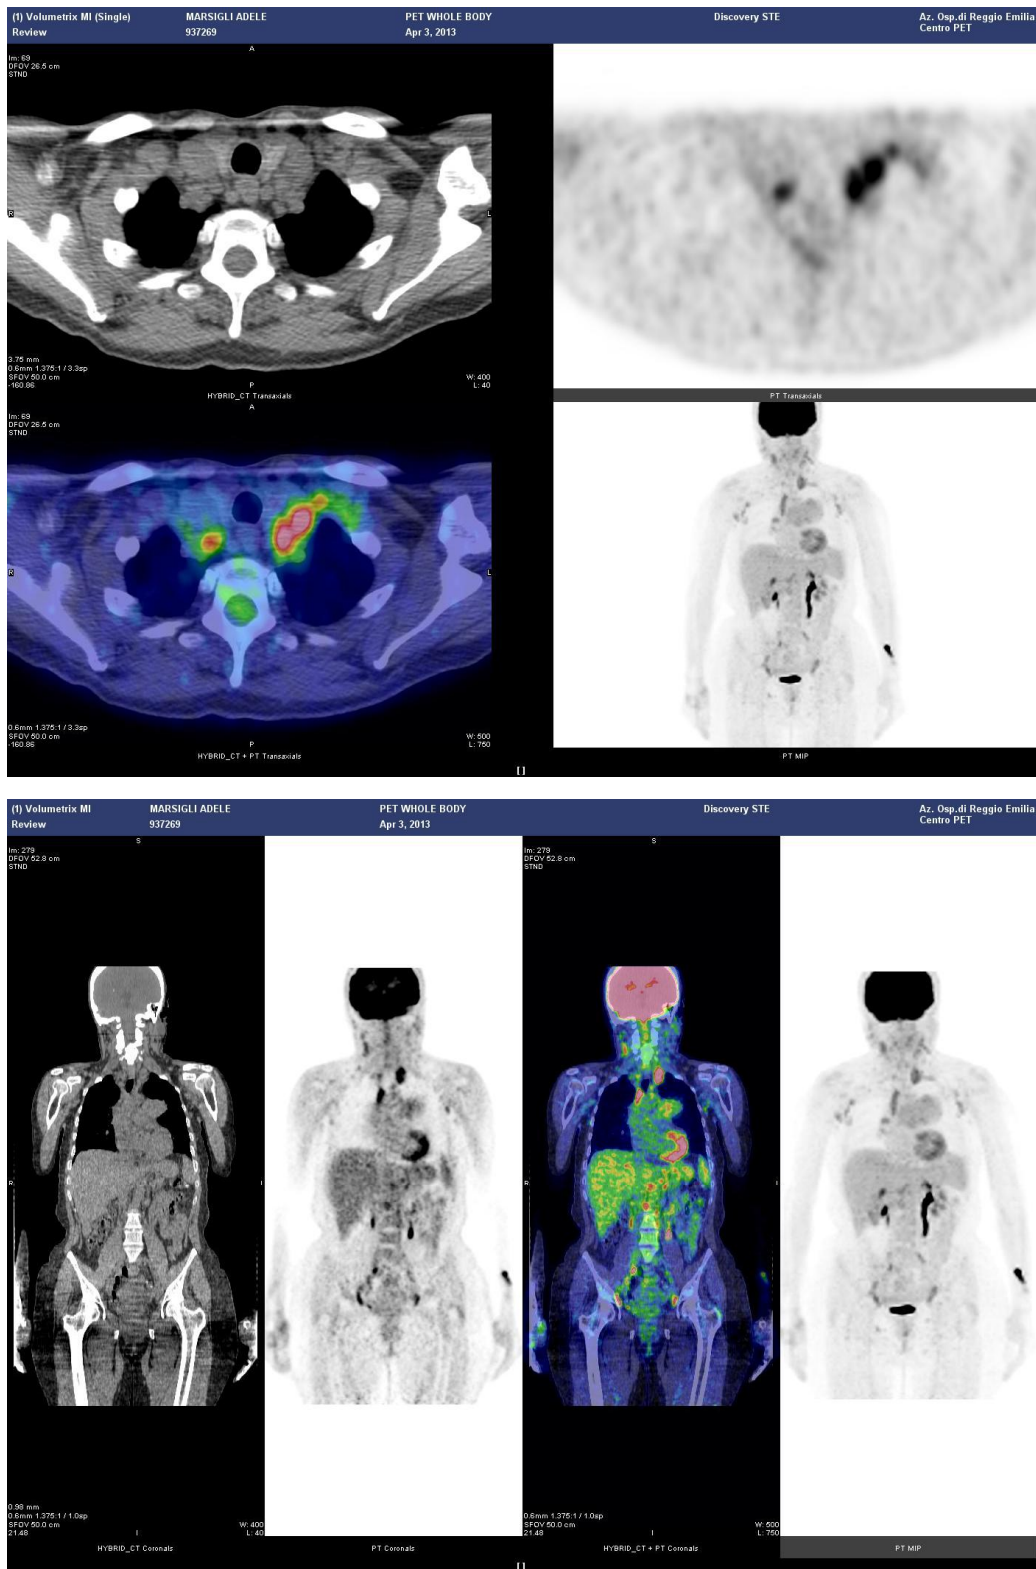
PET/CT scan showing numerous areas of moderate hypermetabolism, with a maximum SUV of 4.7, both above and below the diaphragm, compatible with lymphoma
